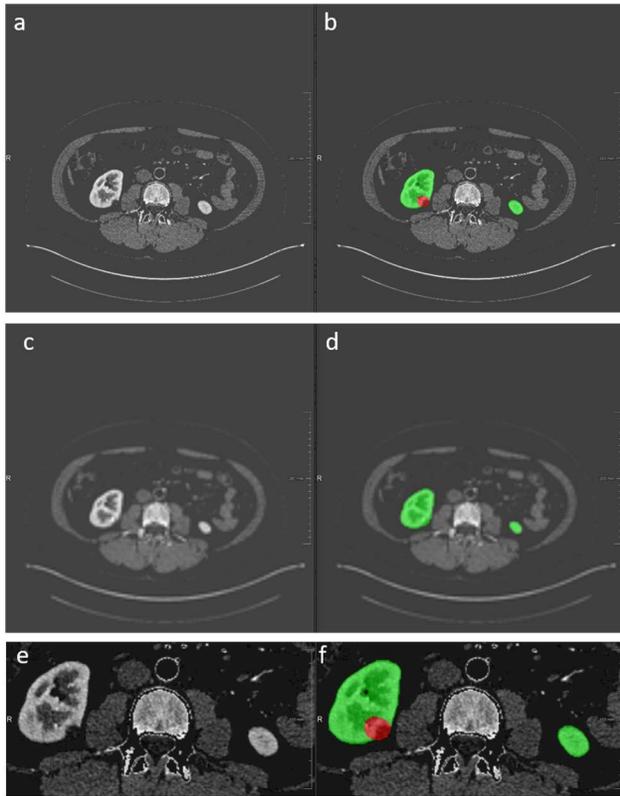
A) Original CT image with resolution 512x512. B) Ground kidney (Green) and tumor (red) overlaid on original image. C, D) An example of 2D axial slice of low-resolution(128x128) preprocessed 3D CT images used as input to stage1. The kidney and tumor are considered as a single class and it is shown in green. E, F) An example of 2D axial slice of cropped kidney region used for training in stage 2. The kidney is shown in green and tumor is shown in red.
